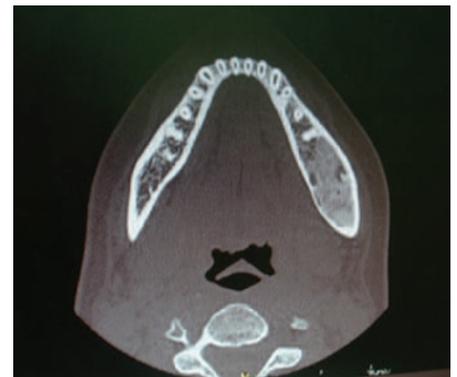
Horizontal CT-mandible scan. Patient's left-side is to the right of the image
